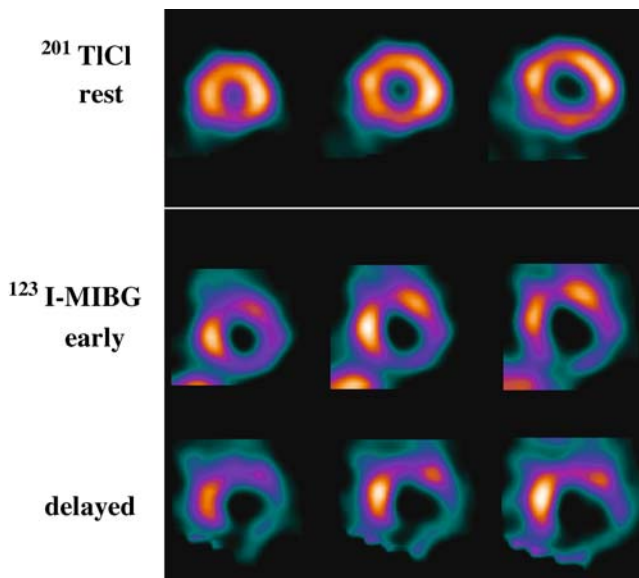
A case of unstable angina in which MIBG facilitated diagnosis. Female, aged 62 years. The patient was admitted to the hospital owing to a diagnosis of unstable angina, but no significant findings were obtained via $^{201}\text{TlCl}$ myocardial perfusion SPECT at rest. MIBG showed decreased accumulation in the inferoposterior wall. On the delayed image, increased washout was observed at the same site, and the abnormal findings became more marked. On coronary angiography, performed later, advanced stenosis was recognized in the proximal part of the right coronary artery
